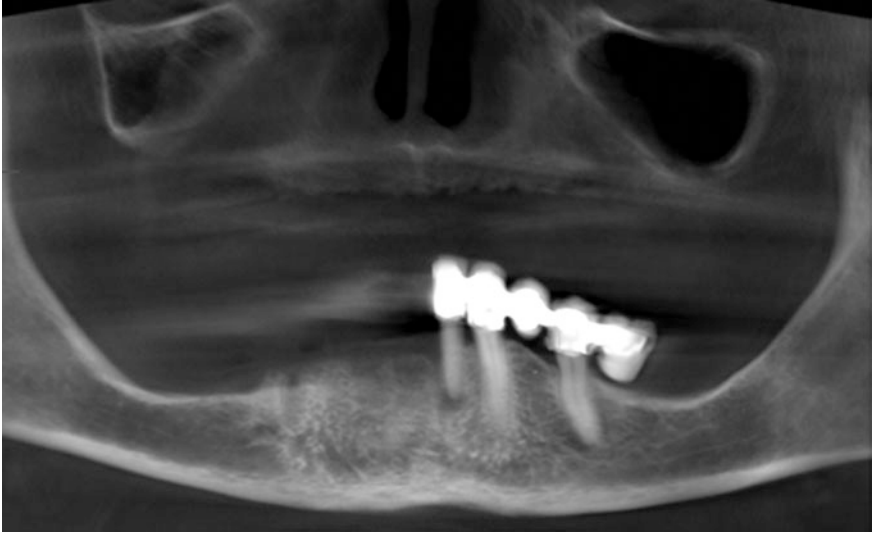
CBCT panorex: pre-operative panoramic image of edentulous maxilla and right branch of mandibular
